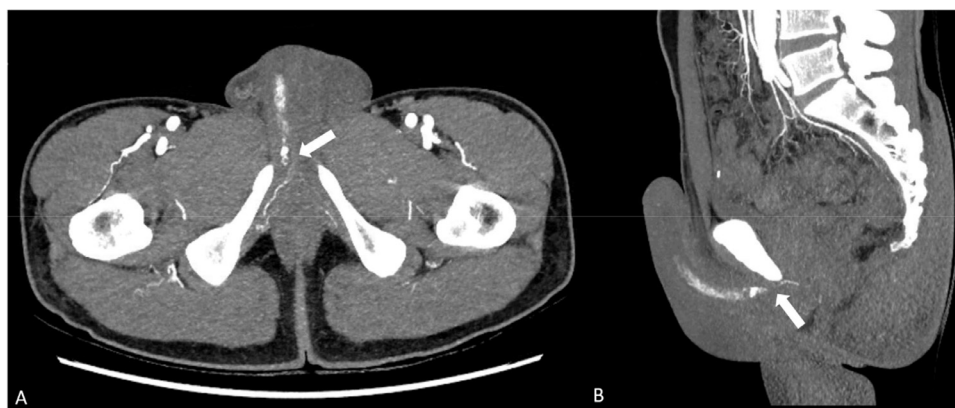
Contrast enhanced 256-row computed tomography scan of the abdomen and pelvis (arterial phase). (A, B) Axial and Sagittal: The right cavernous artery is slightly dilated, the right cavernous venous sinus enhanced early in the arterial phase suggest cavernous arteriovenous fistula (arrow).
